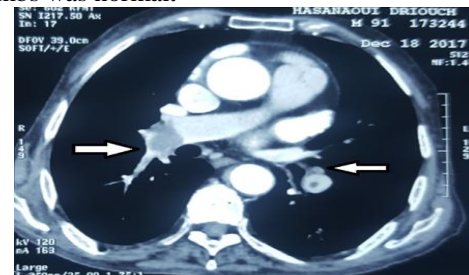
CT Scan : proximal bilateral pulmonary embolism (white arrow)
